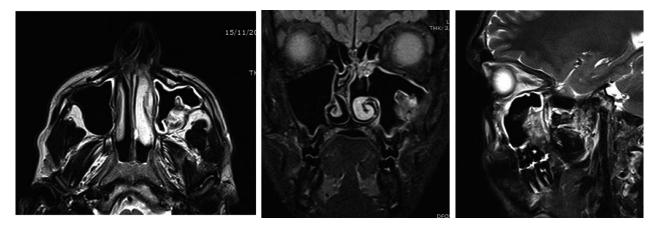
Axial, coronal and sagittal MRI images obtained 6 months after surgery. The fragment in the posterior portion of the sinus appears white and was diagnosed as fibrotic tissue.
